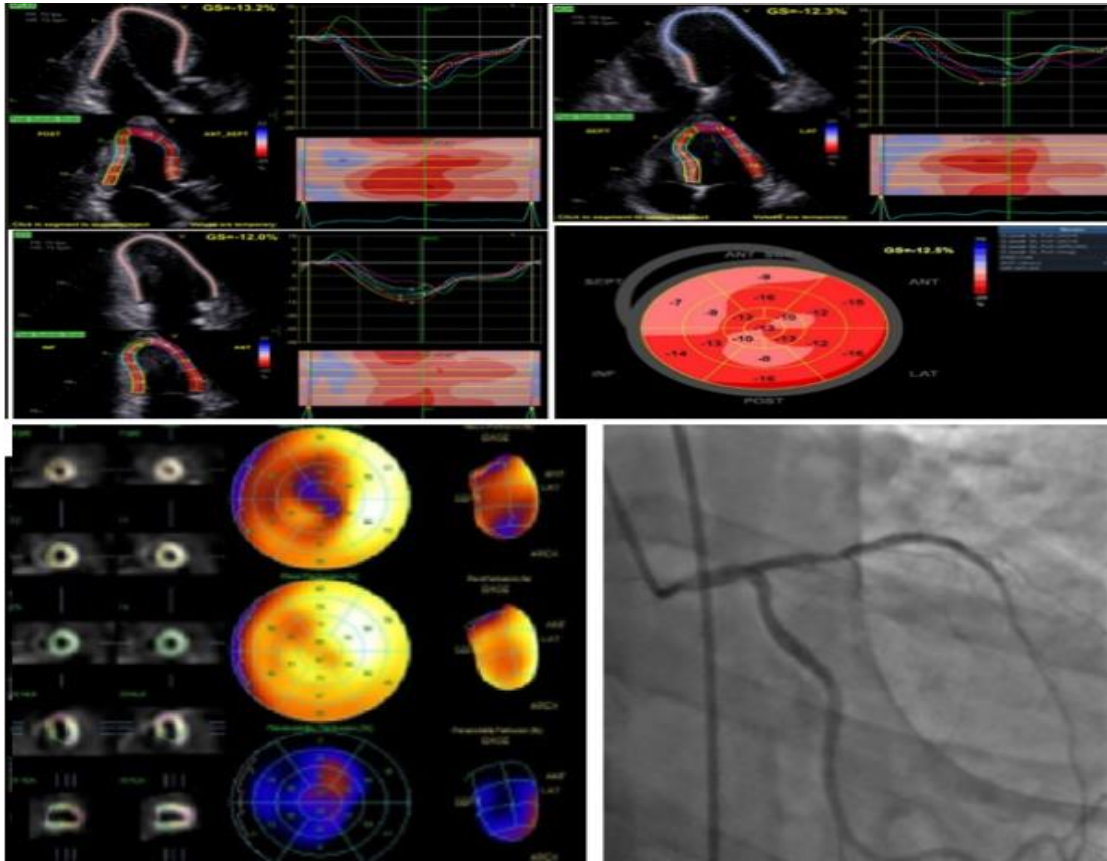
Speckle tracking Echocardiography bull’s eye showing impaired GLS (-12.3) at anteroseptal, septal, apex proper and all apical segments, Segmental MPI, Coronary angiography showing significant lesion at proximal LAD.
